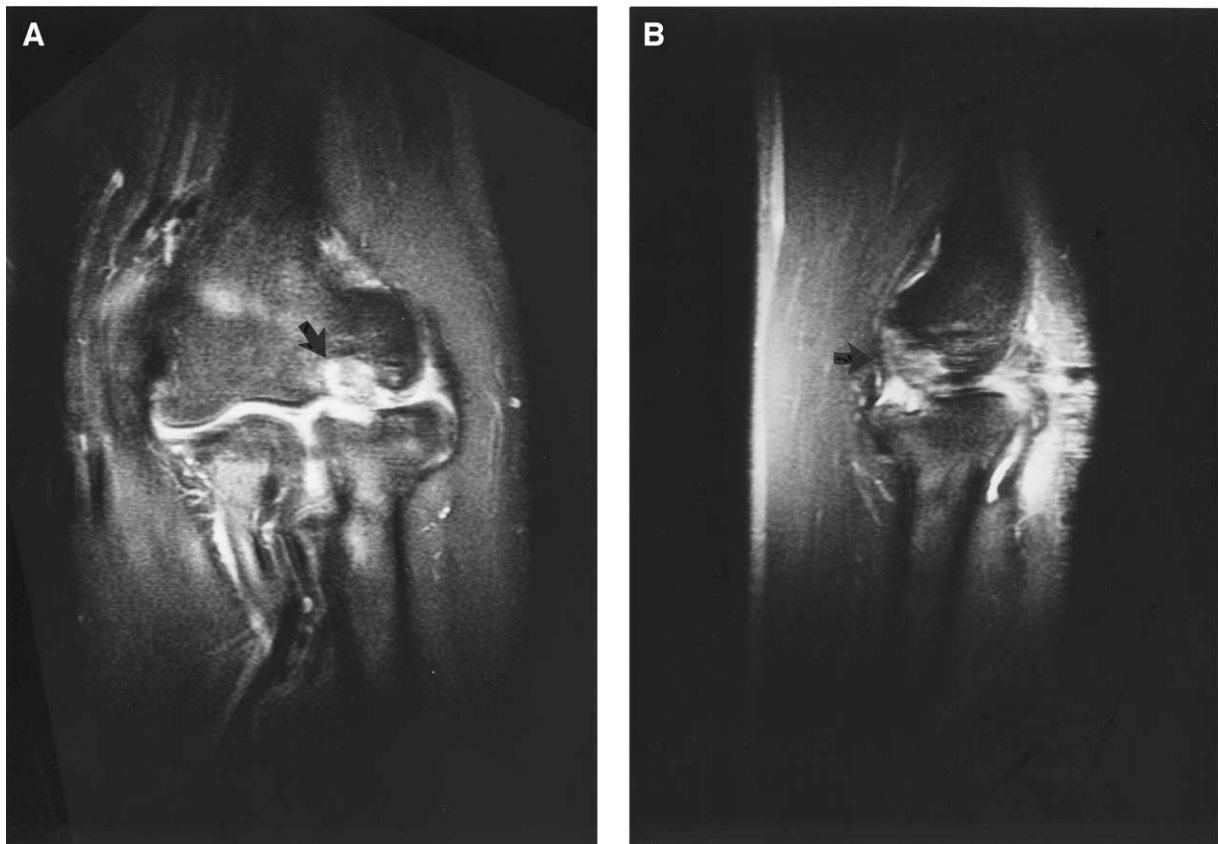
Magnetic resonance images (T_2 -weighted) 24 months after transplantation. The arrow indicates the transplant beneath the periosteal flap. MRIs show the tissue-engineered cartilage of high signal intensity at the grafted site with a subchondral area of high signal intensity. A, Coronal section. B, Sagittal section.
